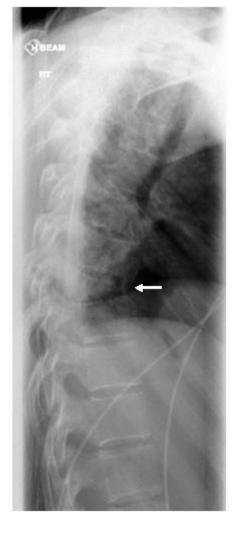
Radiograph showing a wedge fracture of a thoracic vertebra.
